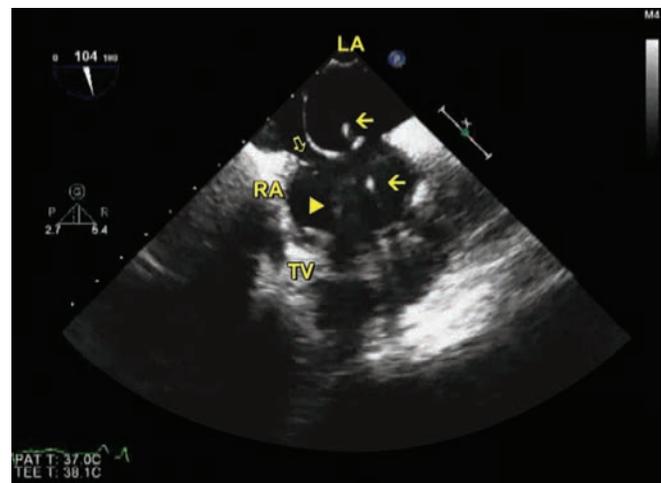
Transesophageal echocardiography. Upper arrow points to the lead in LA while the lower arrow shows the lead in RA. Arrowhead points to thrombus attached to the lead. Hollow arrow points to Eustachian valve.
